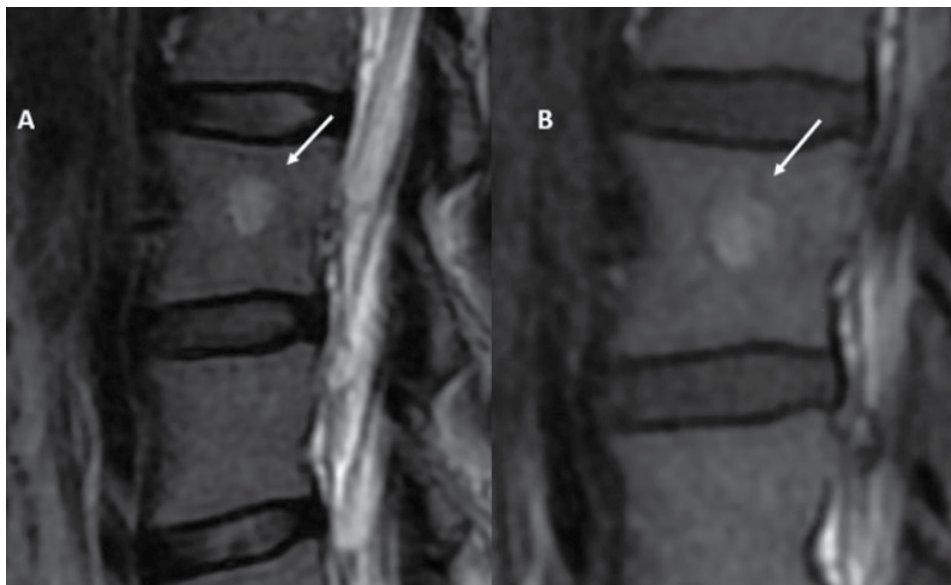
Intraosseous hemangioma: Sagittal MR images of lumbar spine reveal a focal well-circumscribed signal abnormality in the vertebral body (white arrows) that is hyperintense on both T2-weighted (A) and T1-weighted (B) images represent a small vertebral hemangioma.
